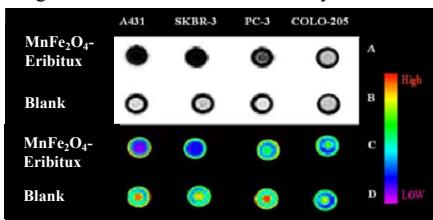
In vitro* T₂-weighted MR images of different EGFR expressed cell line.
